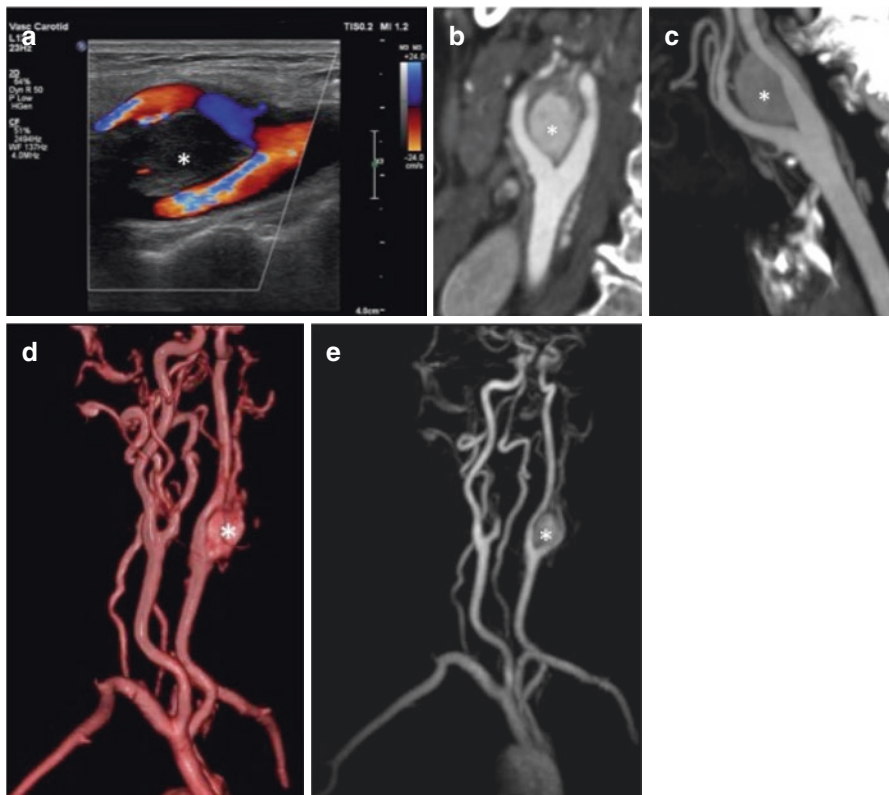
Paranglioma of the carotid bifurcation. Solid oval neoplastic lesion at the level of the left carotid bulb bifurcation (*), hypoechoic on Doppler-US (a), hypervascular on CTA with oblique (b) and 3D MIP (c) reconstructions, and also on MRA with 3D VR (d) and 3D MIP (e). The lesion widens the space between the internal and external carotid arteries' origins and displaces posteriorly the internal jugular vein (that remains patent)
